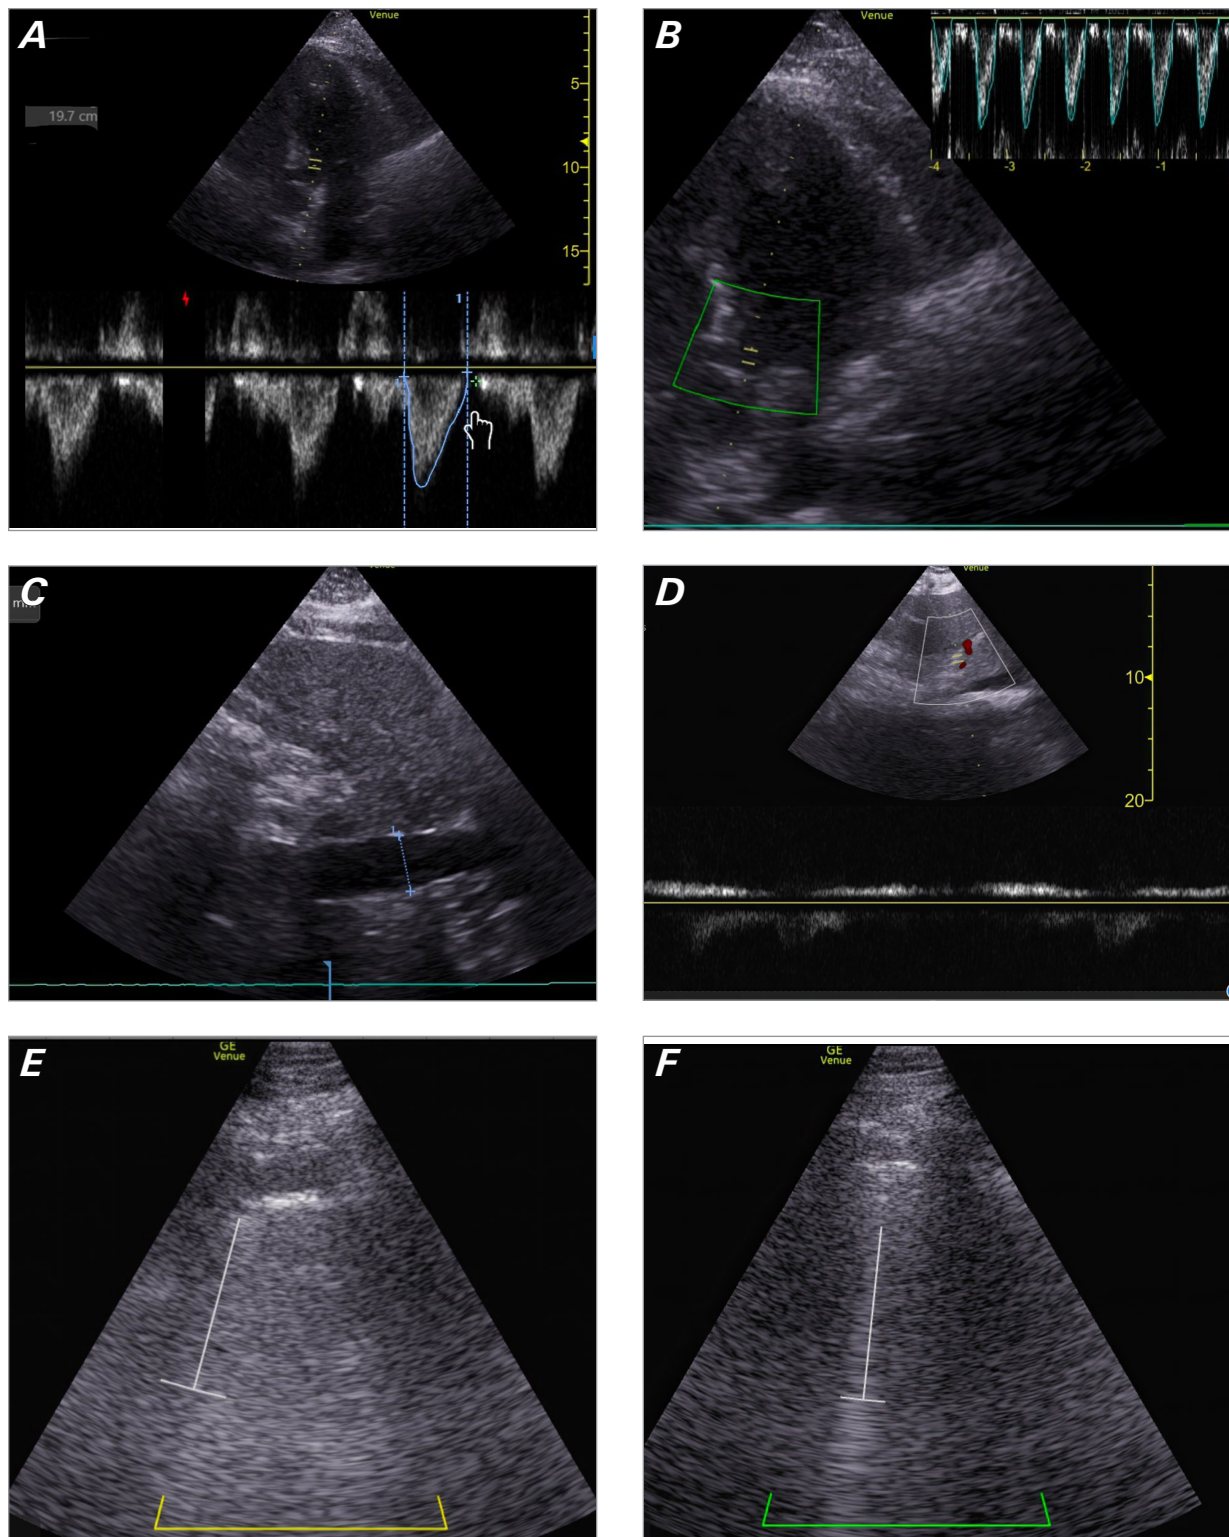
Transthoracic echocardiogram from case 2. A) Left ventricular outflow tract velocity time integral measuring 20 cm, with correct position and angle. B) Automated ultrasonography velocity time integral variability tracing shows no variability. C) The inferior vena cava diameter was 2.5 cm with minimal collapsibility, consistent with elevated central venous pressure of more than 15 mm Hg. D) Portal vein Doppler image showing normal continuous and monophasic flow. E,F) Posterobasal lung zones showing a bilateral B-line pattern suggestive of increased extravascular lung water.
